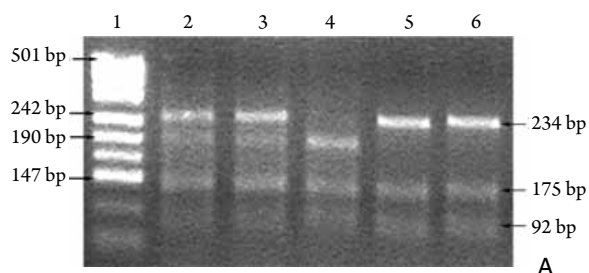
RFLP analysis of the AR C-106T polymorphism (A) and verification of genotyping by direct sequencing (B). Lane 1: DNA ladder marker; Lane 2–3: Heterozygous CT with 4 fragments of 234, 175, 92 and 59 bp; Lane 4: Homozygous CC individuals with 2 fragments of 234 and 92 bp; Lane 5–6: Homozygous TT with 3 fragments of 175, 92 and 59 bp. I: CC genotype; II: CT genotype; III: TT genotype.
